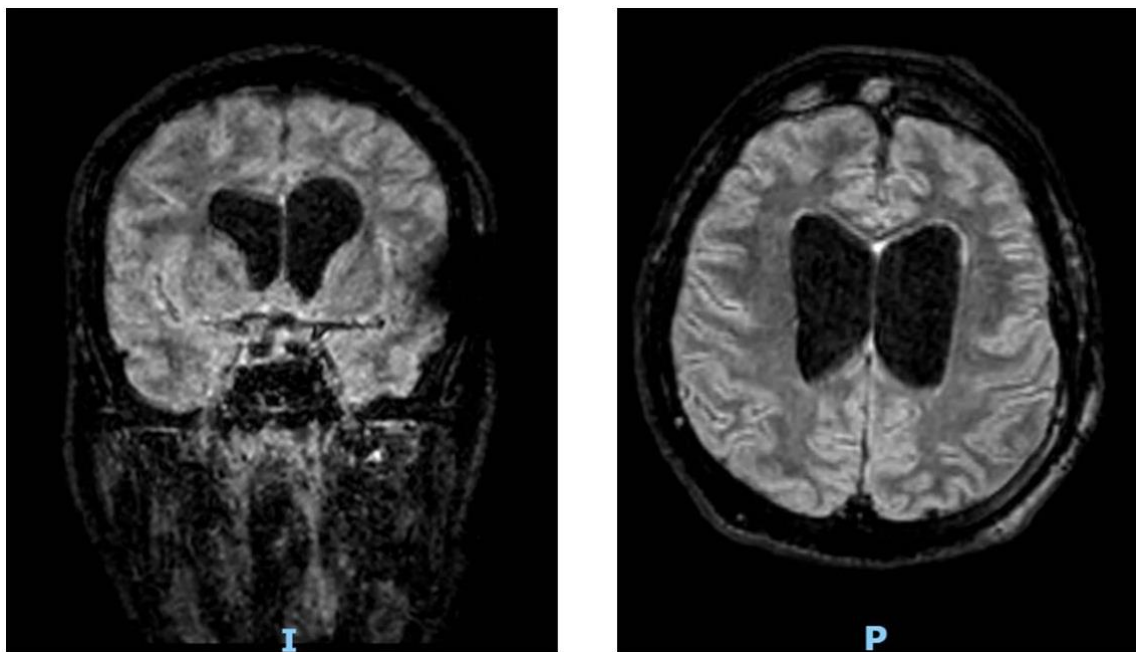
Magnetic Resonance Imaging (MRI) of the patient.
